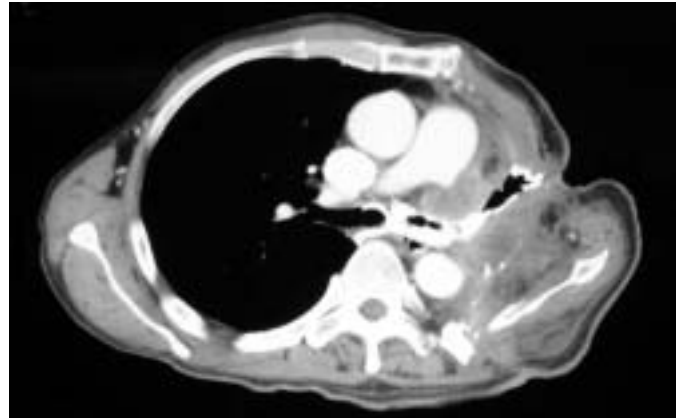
Chest computed tomography scan.
